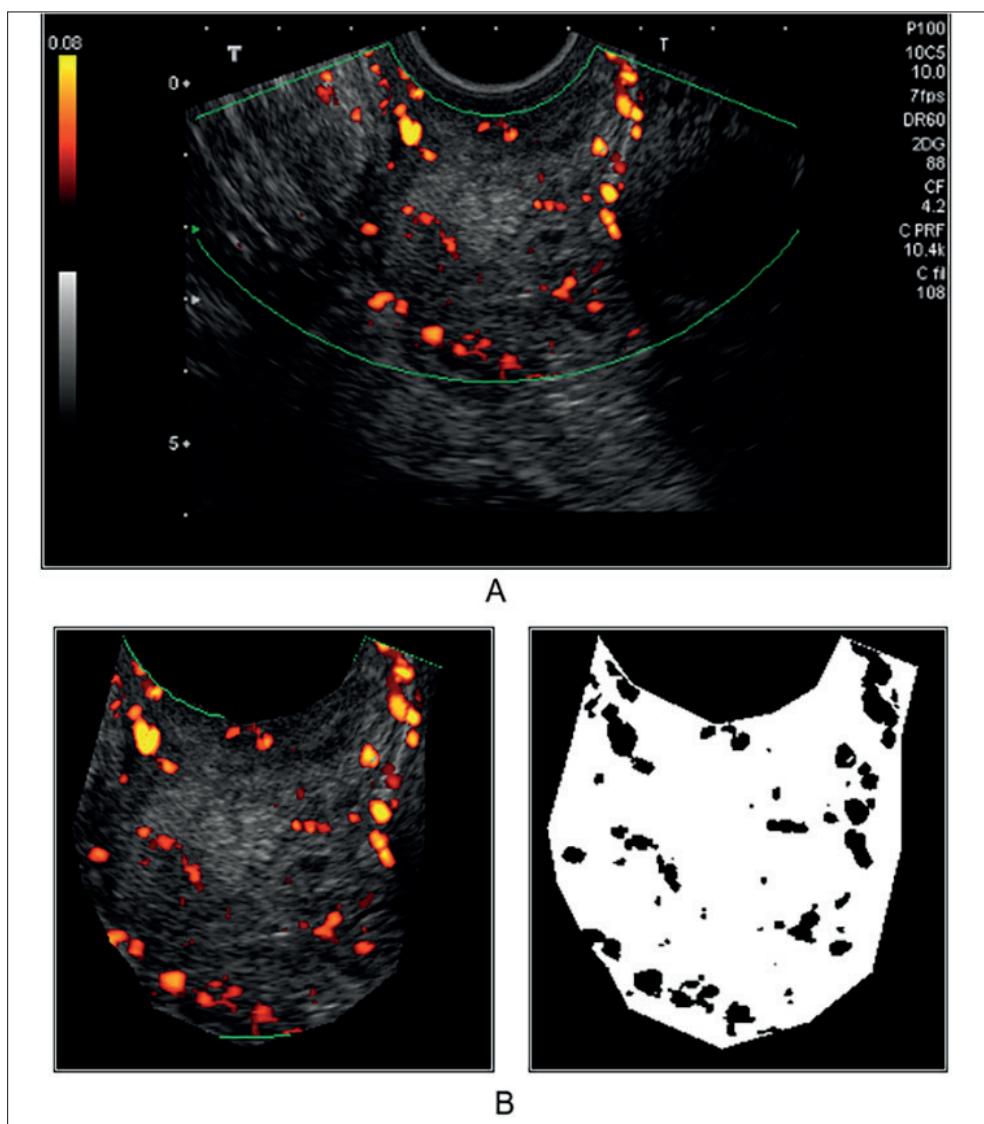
Power Doppler Vascularity Index for digital tumor vascularization assessment. (A) The color window is set to include the lesion and a small part of the surrounding normal tissues. (B) The tumor image is traced with the pointer, followed by a computer-assisted calculation of the percentage ratio of the number of colored pixels within a delineated tumor section to the number of total pixels in that specific tumor section.
